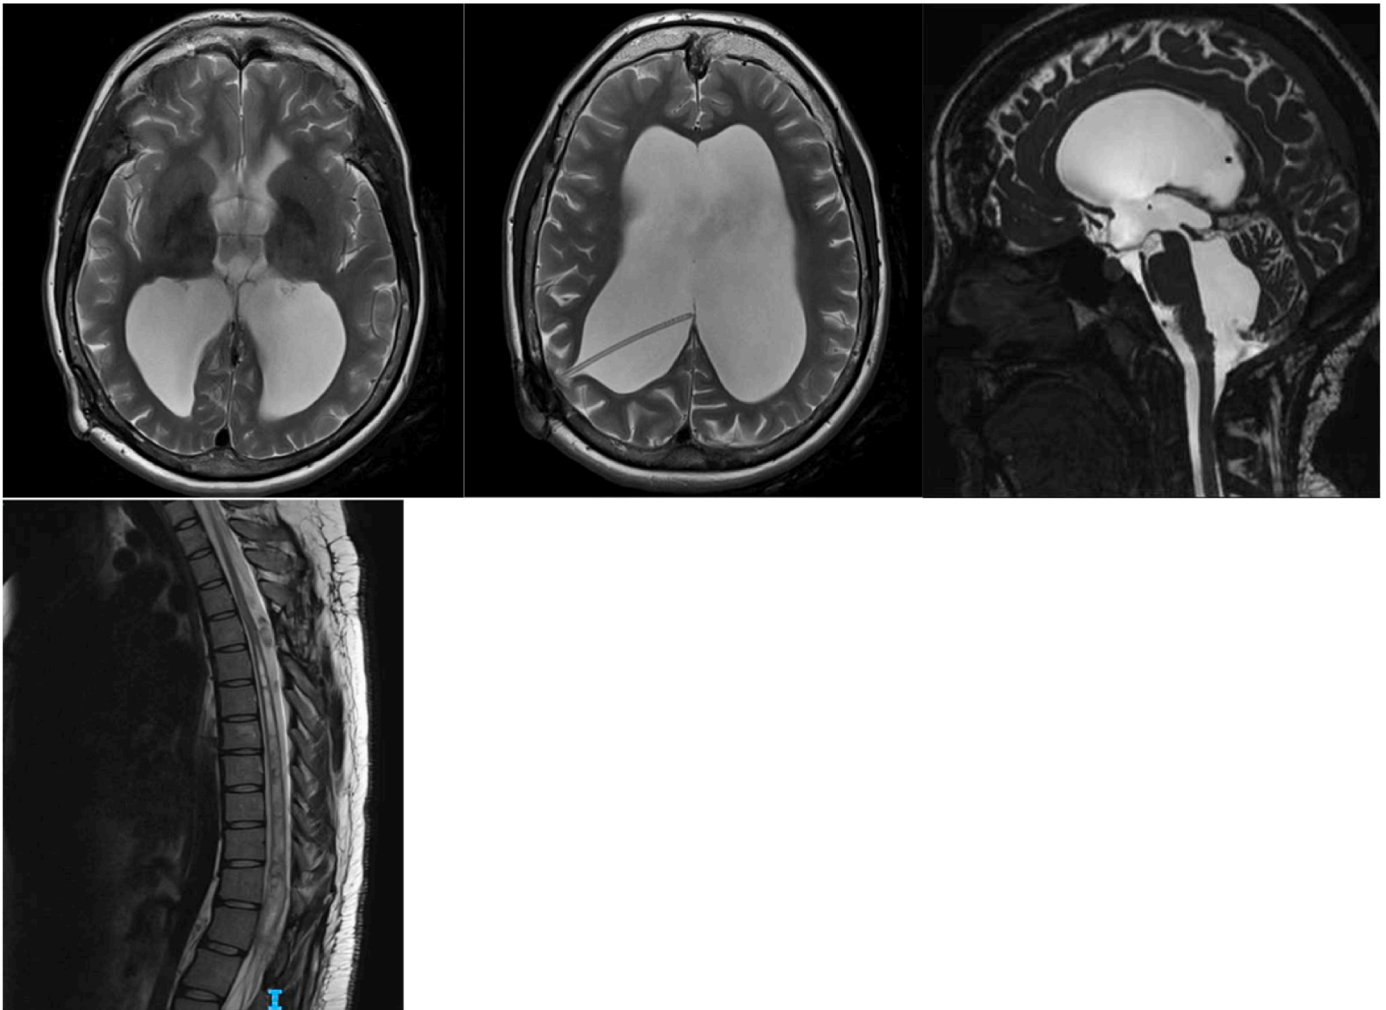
CISS and T2 MRI slices of the brain and spinal cord after the theophylline treatment was commenced.
